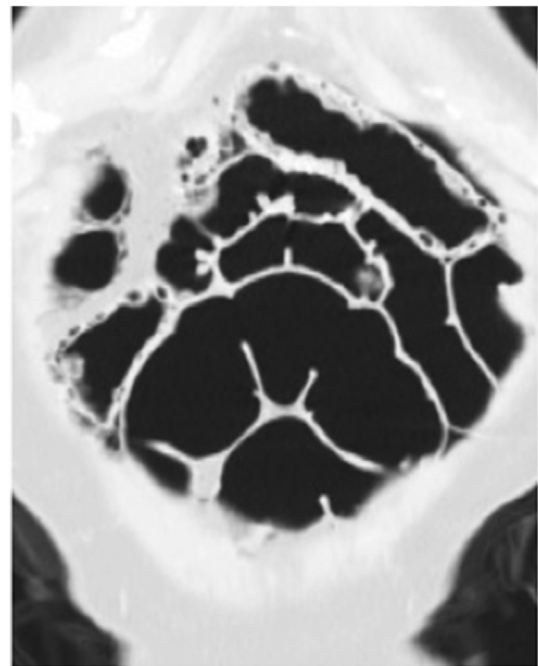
Coronal CT image at the 3.5 month follow up after diagnostic laparoscopy demonstrating substantially disappearance of the sign of PI.
